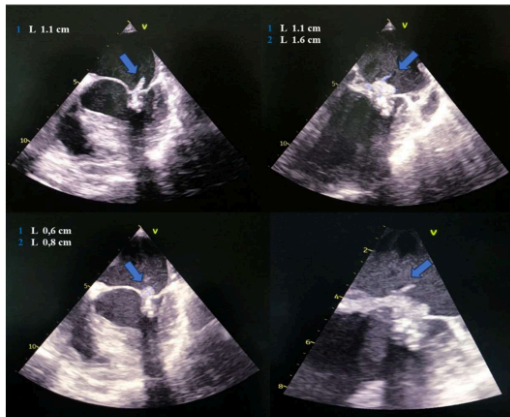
Transesophageal echocardiography (TEE) demonstrating an 11 mm obstructive vegetation attached to the distal third of the anterior mitral valve leaflet, with fine added elements (blue arrow)
